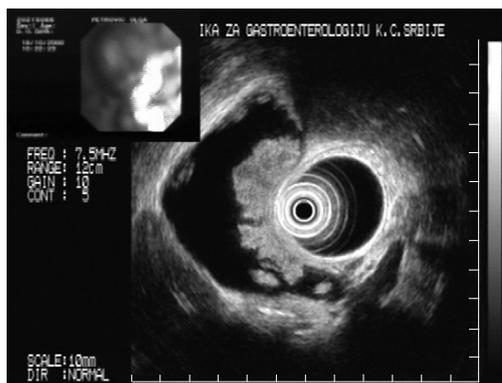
Endosonography picture of the gallbladder polyp.
